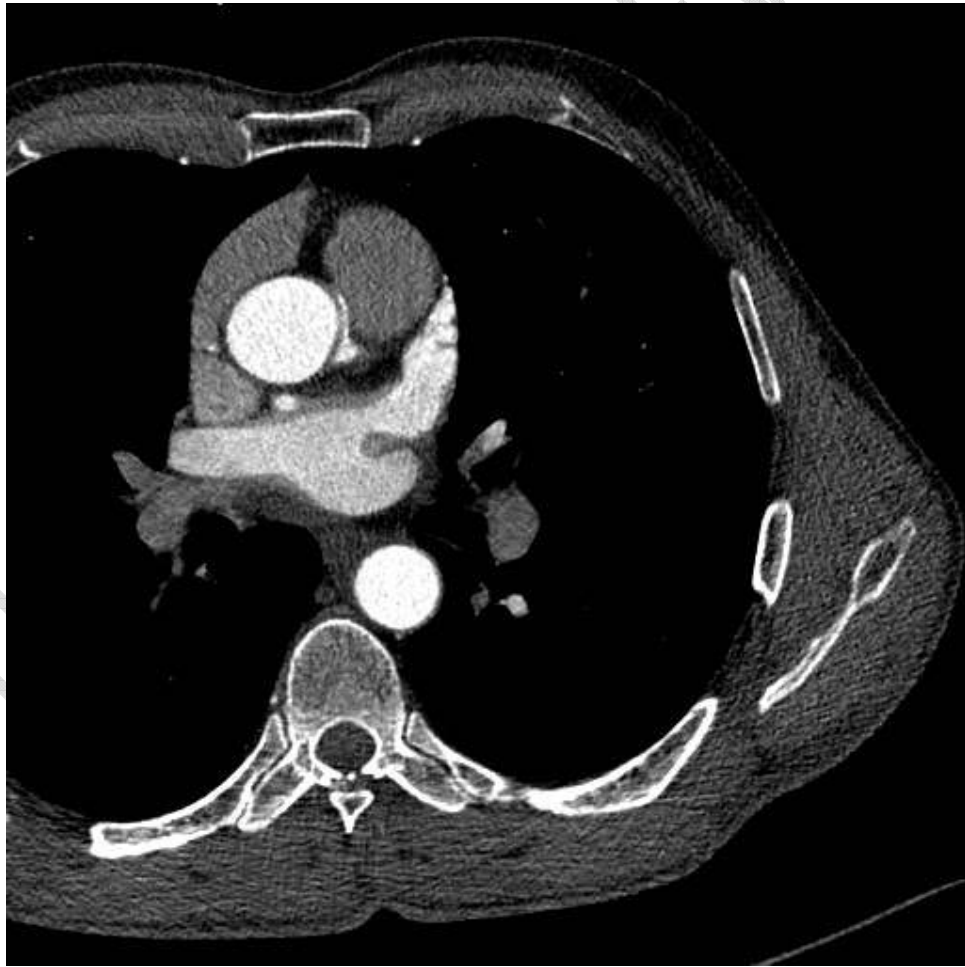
CT coronary angiography showing malignant course of RCA between aorta and pulmonary artery.
